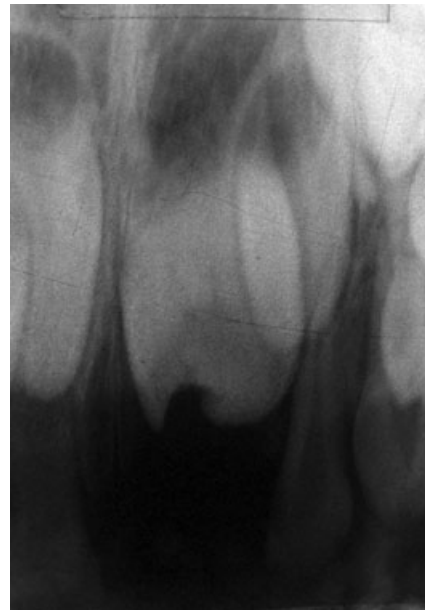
A periapical radiograph taken 6 months after the extraction exhibiting a crown malformation on the permanent maxillary left central incisor.
